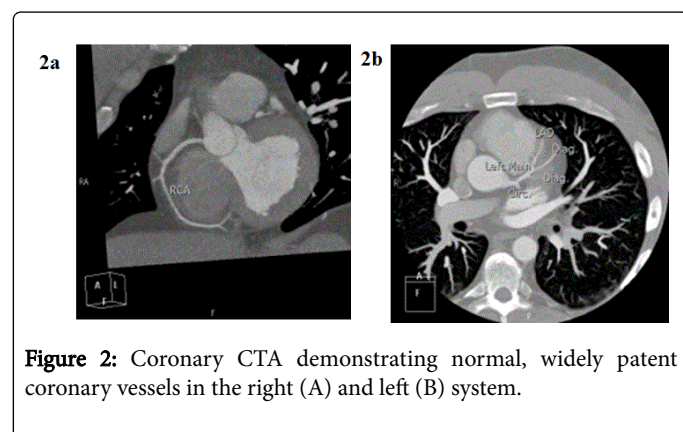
Coronary CTA demonstrating normal, widely patent coronary vessels in the right (A) and left (B) system.
